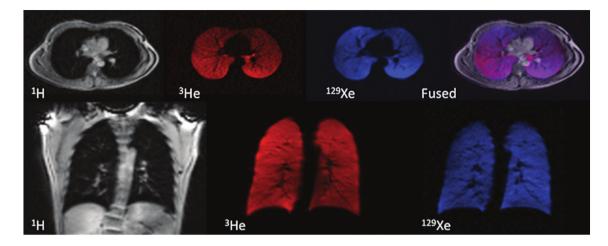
MR images of ¹H (grey), ³He (red) and ¹²⁹Xe (blue) acquired from a healthy volunteer in the same breath-hold containing 600 mL of ¹²⁹Xe and 300 mL of ³He. The anatomic ¹H images show excellent spatial registration with the ³He and ¹²⁹Xe ventilation images, as demonstrated by the overlaid fused image (purple). Figure reproduced with permission from Reference³⁷
